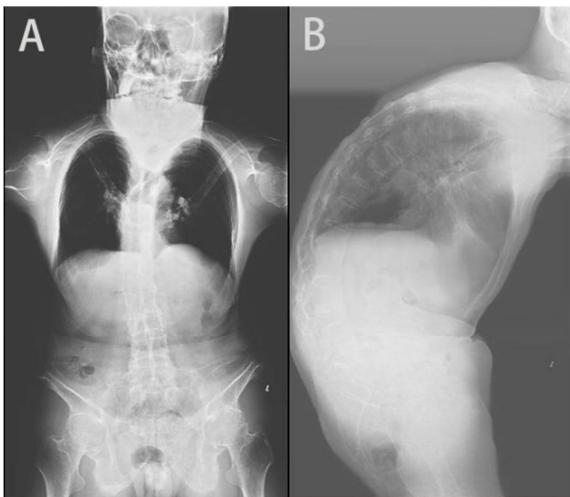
Spinal X-ray before operation: 1, Scoliosis, Kyphosis; Ankylosing spondylitis.
